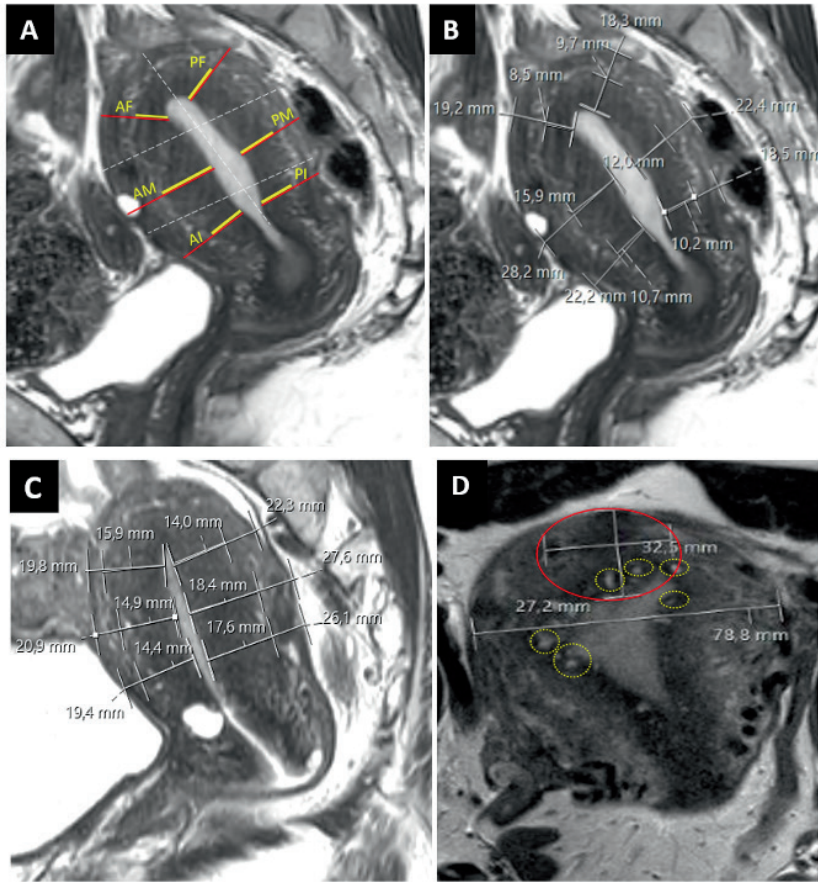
Measurements on MRI of Adenomyosis characteristics. All MRI images shown were performed on a T2-TSE. Figure A, B and C are shown in a sagittal plane, D in the transverse plane. A; The JZ thickness (yellow line) and the myometrium thickness (red line) measured at the level of fundus (F), mid-corpus (M) and isthmus (I) in the anterior (A) and posterior (P) wall of the uterus. B; The measurements of JZ thickness and myometrium thickness. C; A uterus with diffuse adenomyosis with a JZ \geq 12 mm. D; Uterus volume determination using the width in the transverse plane (78.8 mm). JZ is showing high signal intensity foci's determined with dashed yellow circles. Volume of focal adenomyosis shown in the red circle
